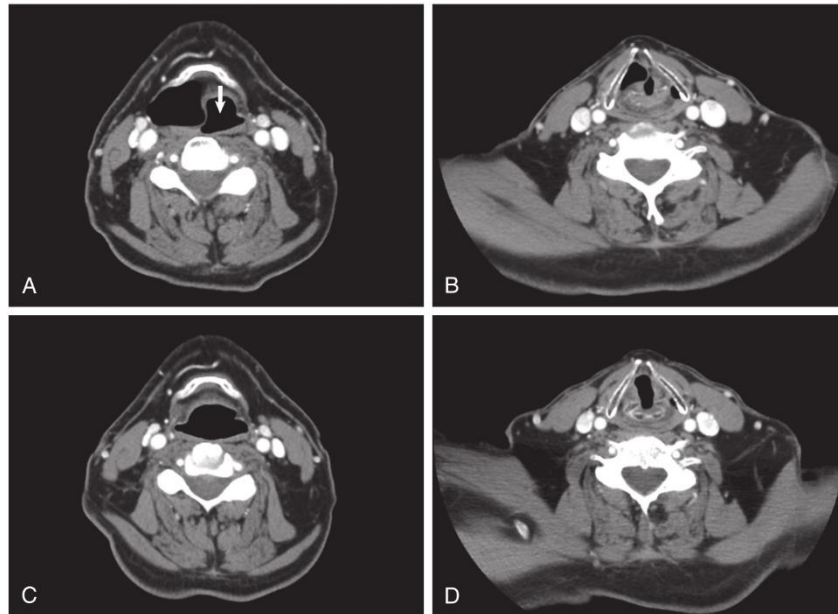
Laryngocele (air-filled variant of saccular cyst) in preoperative and postoperative computed tomography scans. A, Preoperative view of a large air-filled sac that pushes the epiglottis (arrow) to the patient's left. B, At the level of the ventricle, the opening to the dilated saccule is shown. C, Postoperative view. D, Postoperative view.
